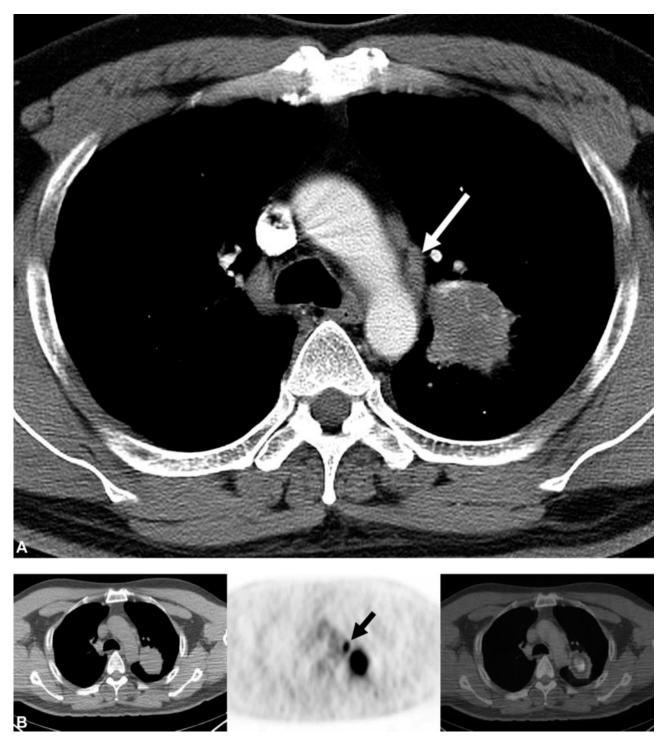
True-positive mediastinal lymph node metastasis at integrated PET/CT in a 53-year-old man with lung adenocarcinoma. (A) Mediastinal-window transverse enhanced CT scan (5.0-mm collimation, 170 mA) obtained at level of azygos arch shows 3.6-cm-sized mass in left upper lobe and 6.0-mm-sized lymph node (arrow) in short-axis diameter in aortopulmonary window area (nodal station, 5). (B) Integrated PET/CT scans obtained at a similar level to a demonstrate node showing strongly increased FDG uptake (maximum SUV = 7.4) (arrow) suggesting malignant node, which proved to contain metastatic adenocarcinoma cells.
